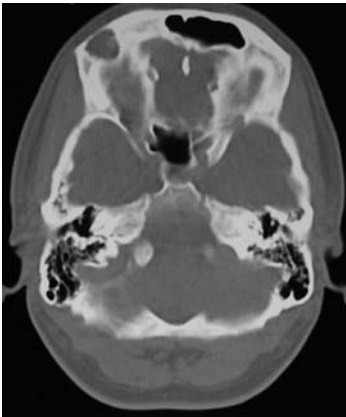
Male, 23 years of age, with orbital headache that is drug-resistant. Projections of skull CT with sequences reconstructed in axial view. Eosinophilic granuloma.
